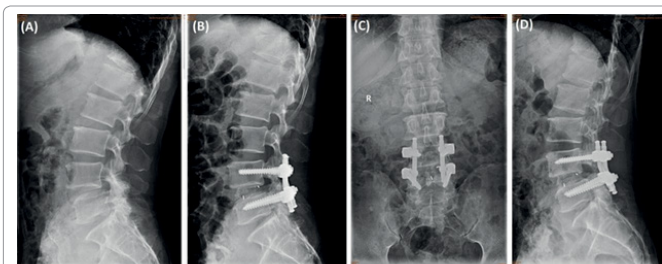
A 56-year-old man with isthmic spondylolisthesis at L4-L5 level (A) Preoperative lateral radiograph showed that slippage was 23.4% and focal lordosis was -2.8. (B,C) Immediate postoperative lateral and anteroposterior X-ray showed that complete reduction of the spondylolisthesis (D,E) Final follow-up lateral and anteroposterior X-ray showed that complete reduction of the spondylolisthesis.
